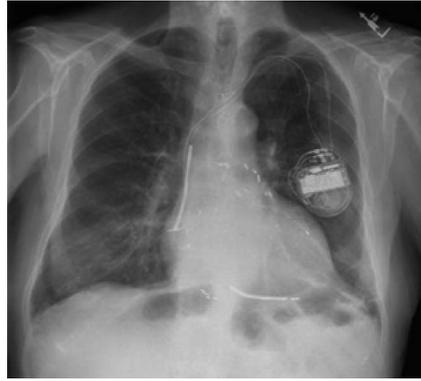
Chest X-ray demonstrating bi-ventricular implantable cardioverter defibrillator.
